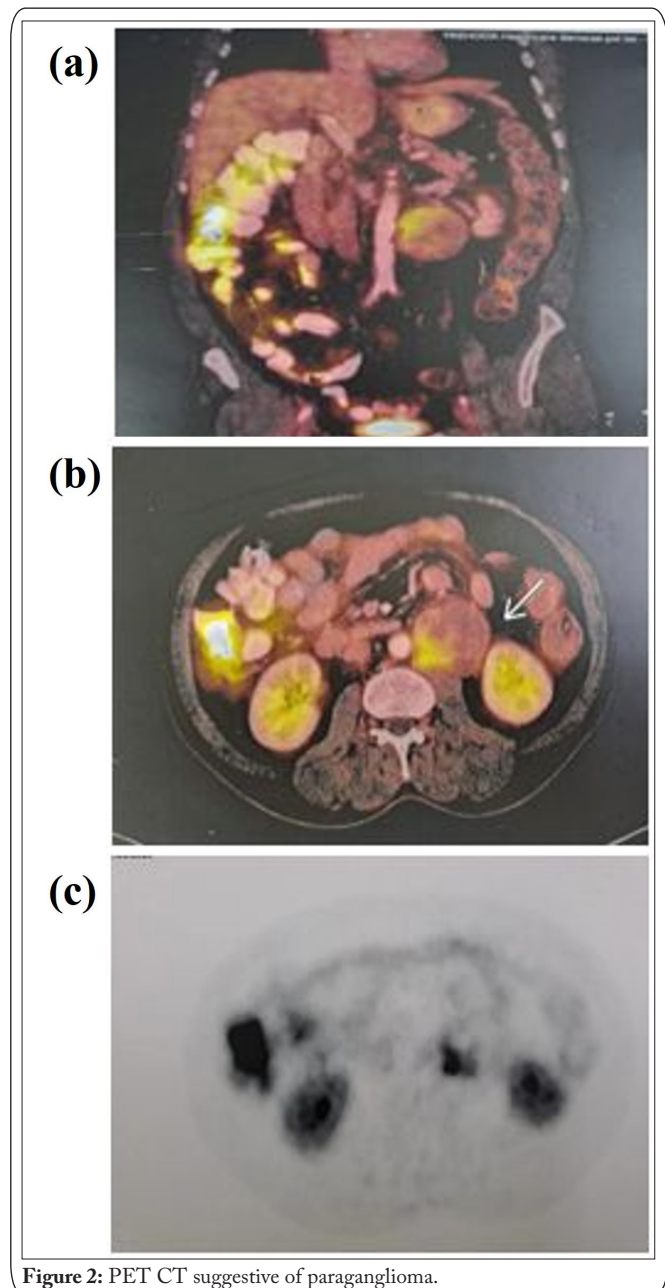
PET CT suggestive of paraganglioma.
